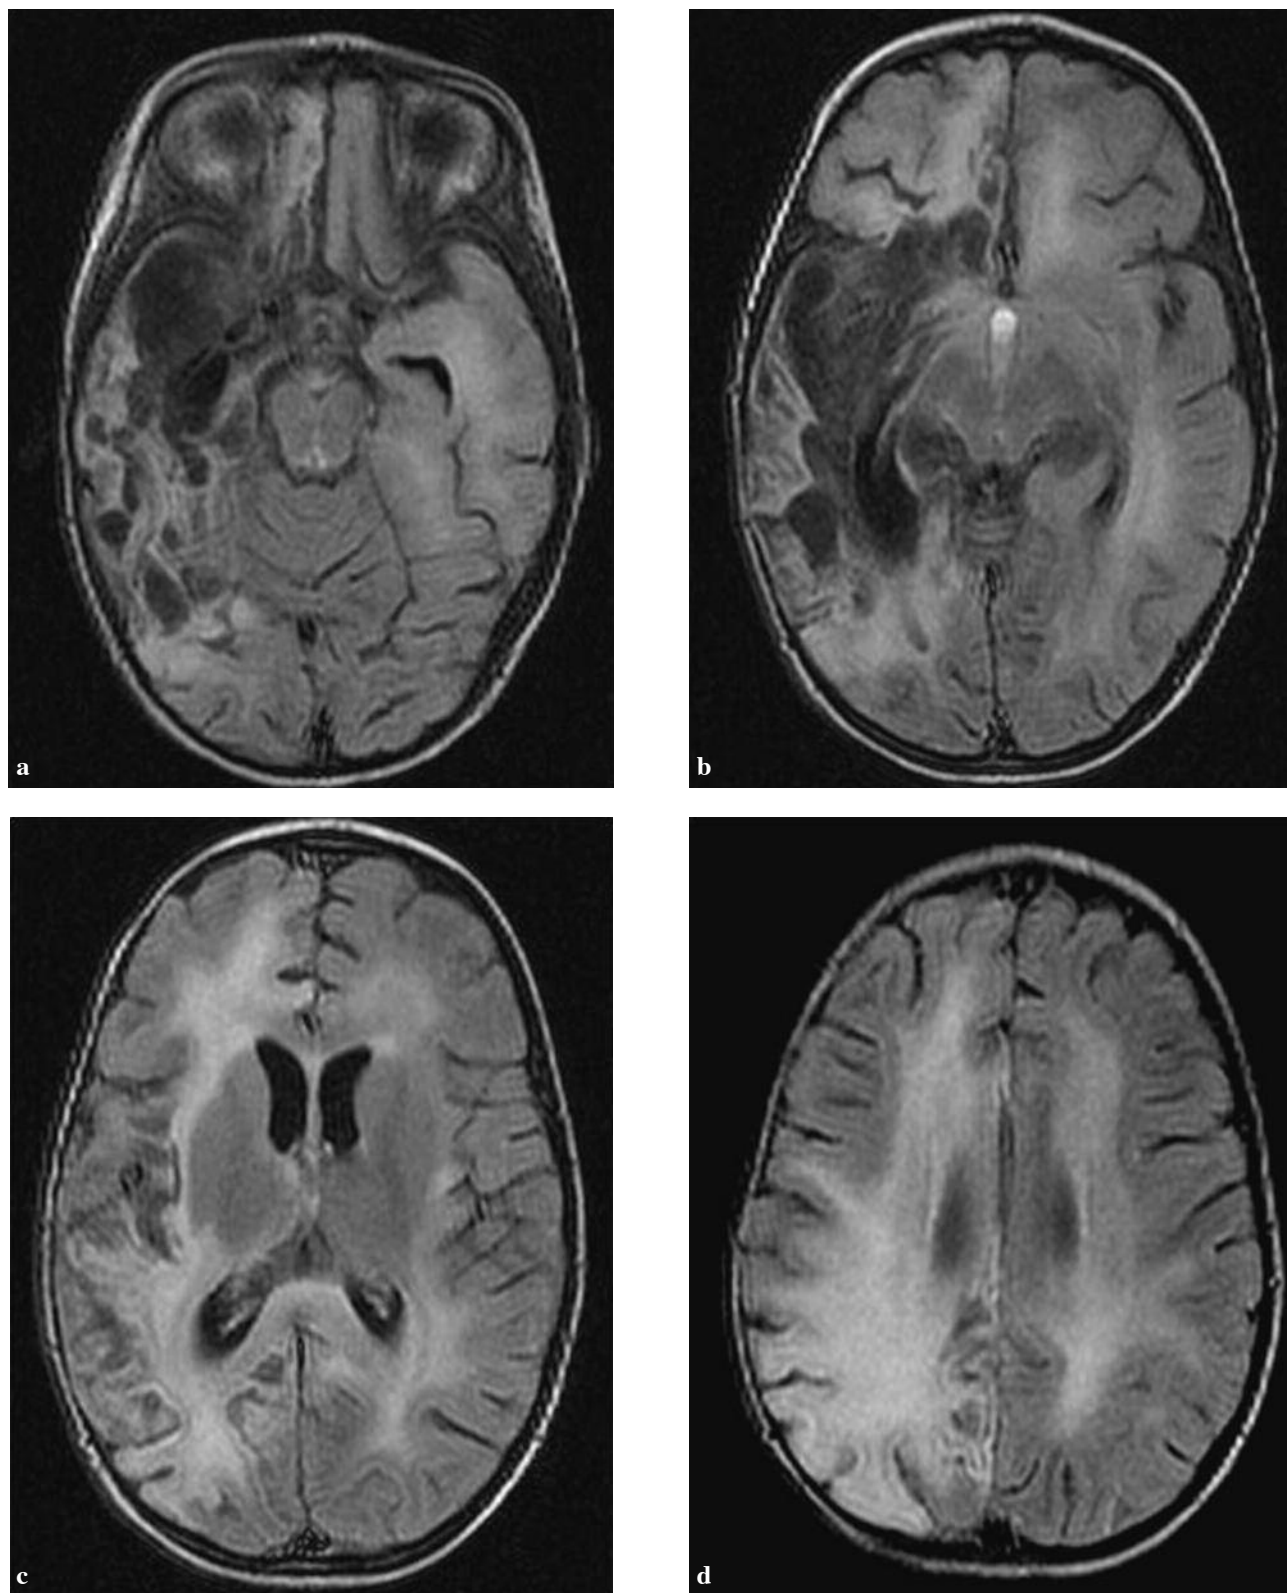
Initial brain MRI: Widespread hyperintensities on axial FLAIR images in the temporal, insular and frontal regions (Fig. 1a, 1b and 1c). Haemorrhage is hyperintense on T1 weighted-images (Fig. 2). Gad-enhanced T1 weighted-images show discrete gyriform enhancement (Fig. 3).
